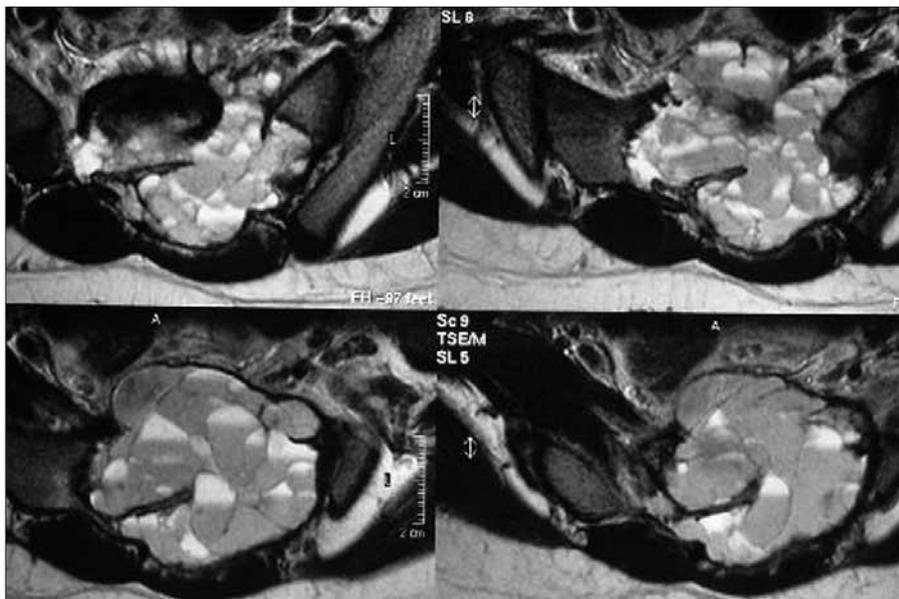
Serial axial T2-weighted MR images show an expansile, lobulated, lytic, multiseptated, cystic mass on the S2 and S3 vertebrae, which extends to the left neural foramina, sacroiliac joint, and paravertebral soft tissue.
